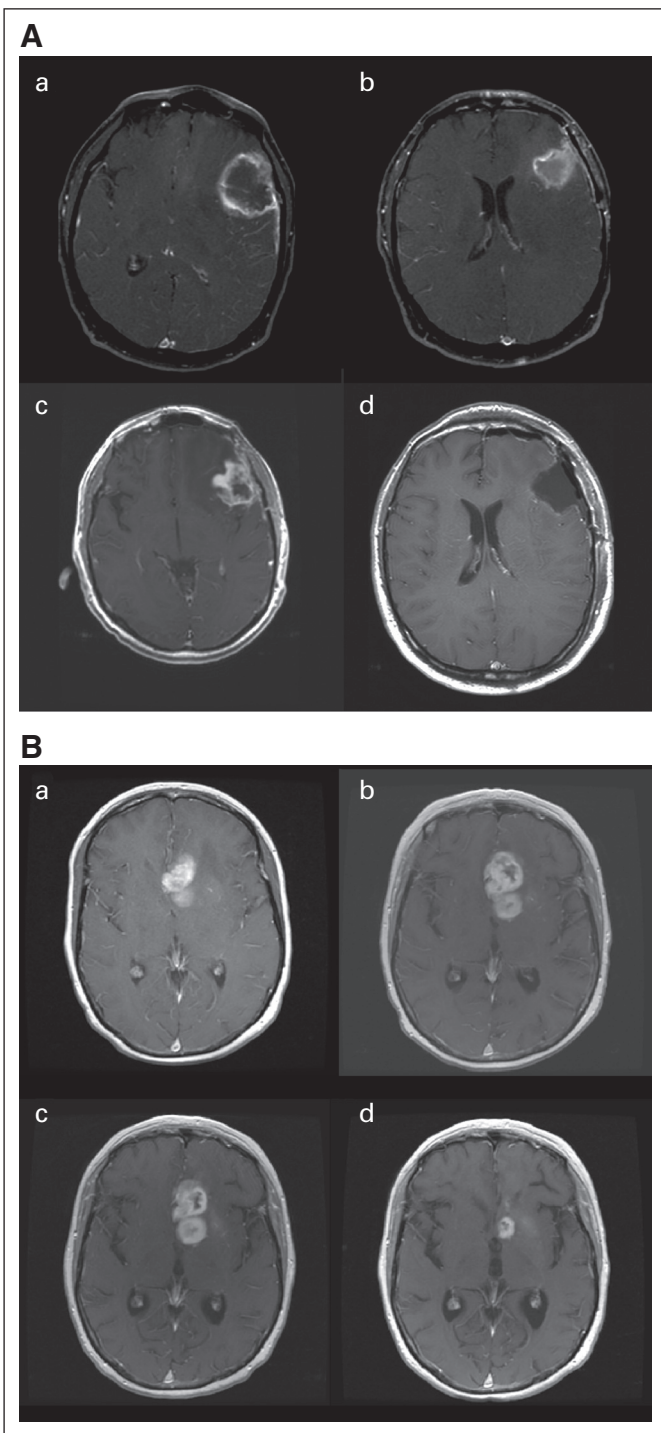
(A) Pseudoprogression after chemoradiotherapy: axial T1-contrast enhanced magnetic resonance imaging (MRI) a) before surgery; b) after surgery; c) after radiotherapy and concomitant temozolomide showing increased enhancement; d) re-operation showing only necrotic tissue and no tumor. (B) Pseudoprogression after chemoradiotherapy: axial T1-contrast enhanced MRI showing deep left frontal glioblastoma a) 2 days after stereotactic biopsy; b) 4 weeks after radiotherapy and concomitant temozolomide showing increased enhancement, raising the possibility of progression; c) after 4 additional weeks of treatment with adjuvant temozolomide showing stable disease; d) after 8 cycles of adjuvant temozolomide showing significant reduction in tumor size.
